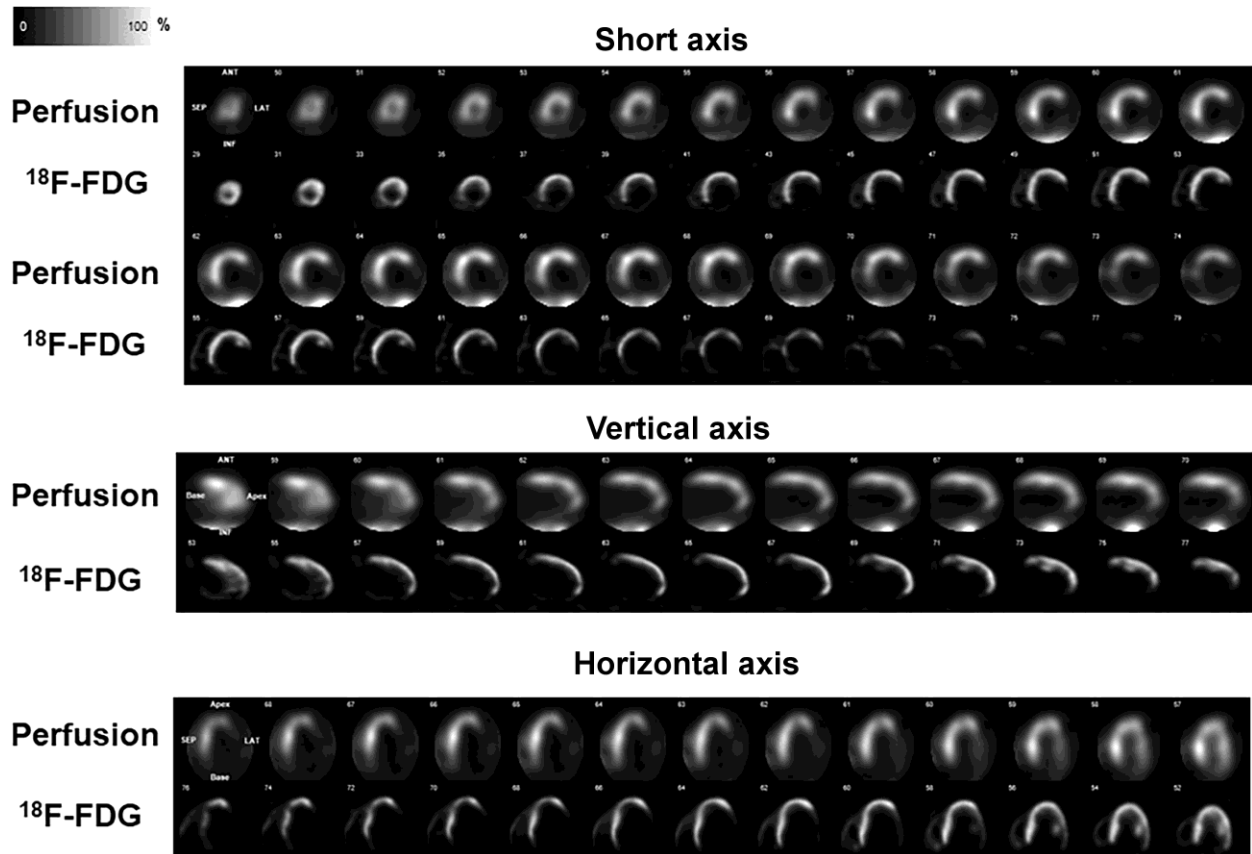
Rest myocardial perfusion SPECT/CT images with ^{99m}Tc -tetrofosmin and ^{18}F -FDG-PET/CT images in a patient with ischemic cardiomyopathy, demonstrating a “match”.
